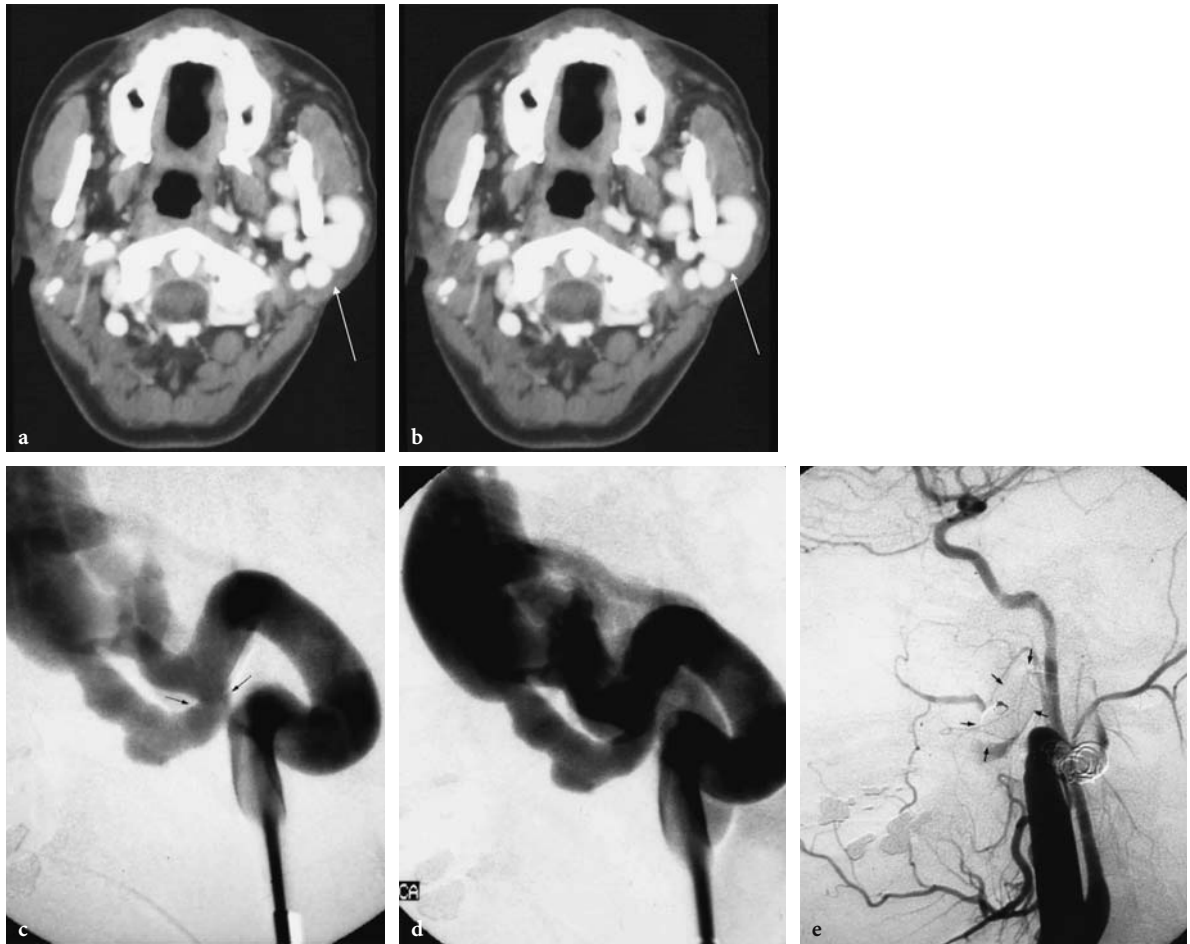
Contrast enhanced CT scans a, b in 12-year-old boy with slowly enlarging pulsatile mass lesion involving the left cheek region demonstrate prominent vascular channels left preauricular area (*arrows*). Left lateral external carotid angiogram in early c and late arterial phase d demonstrated single hole fistulous communication (*arrows*) between proximal internal maxillary artery and adjacent facial vein. Transarterial arterial single balloon detachment was performed at the fistulous site resulting in immediate complete obliteration of the fistula and several coils were deposited in the proximal external carotid artery for added protection. Post-embolization left lateral common carotid angiogram e demonstrated closure of the AVF. Note the cast of the single balloon (*arrows*) and the discrepancy between the grossly enlarged proximal trunk of the external carotid artery versus the size of the internal carotid artery
